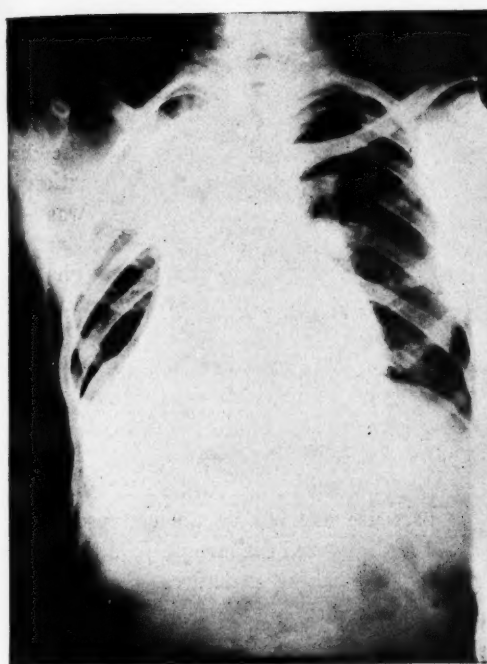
Case 2. Fluoroscopic examination three days later still showed complete collapse. On rolling the patient over for the radiographic examination the lower lobe suddenly re-inflated. The time which elapsed between complete consolidation and re-inflation of the lower lobe was less than five minutes.
